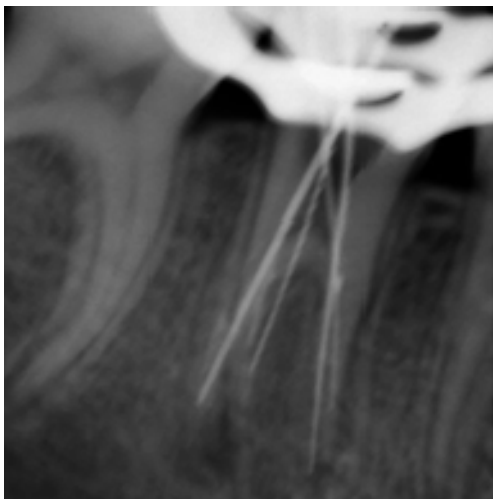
Periapical radiograph of the tooth during the calculation of the working lengths.
